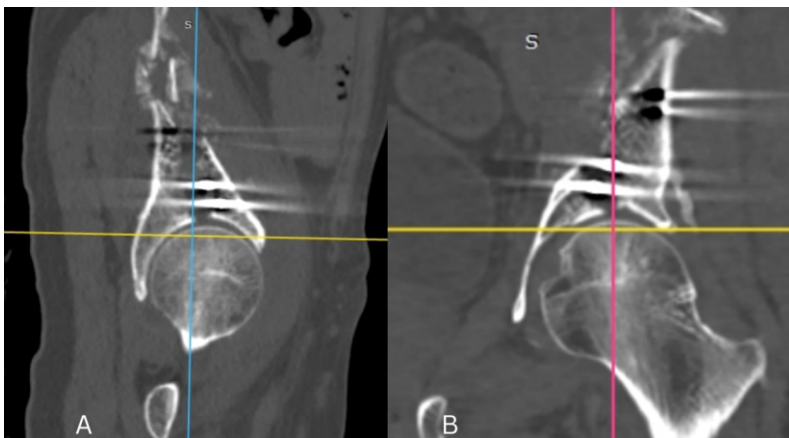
Post-operative computed tomography scan of fracture (A) Sagittal view (B) Coronal view.
